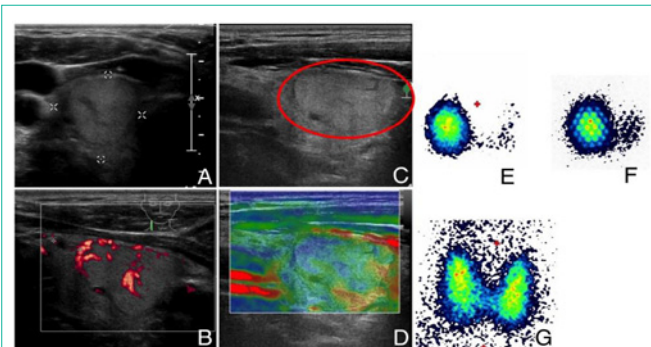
Thyroid nodule right lobe (unifocal autonomy): A: Axial; B: sagittal; C: sonography showing increased perfusion; D: sagittal sonography corresponding to the elastography (nodule marked in red), the elasticity is predominantly soft. E: The scintigraphies show the focal autonomies before radioiodine therapy; F: during radioiodine therapy; and G: At follow-up, the scintigraphy shows a thyroid without focal autonomy.
